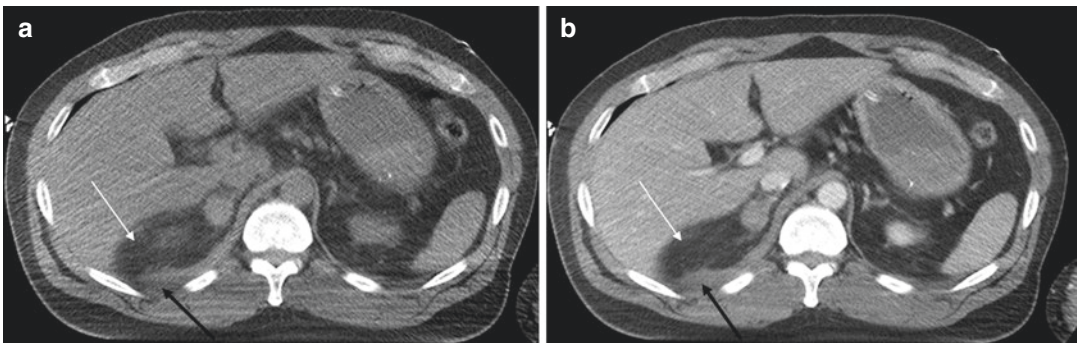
Adrenal hematoma. CT axial images (a–b) show homogeneous swelling of right adrenal gland, which is slightly hypodense in basal phase (a). Periadrenal fat
